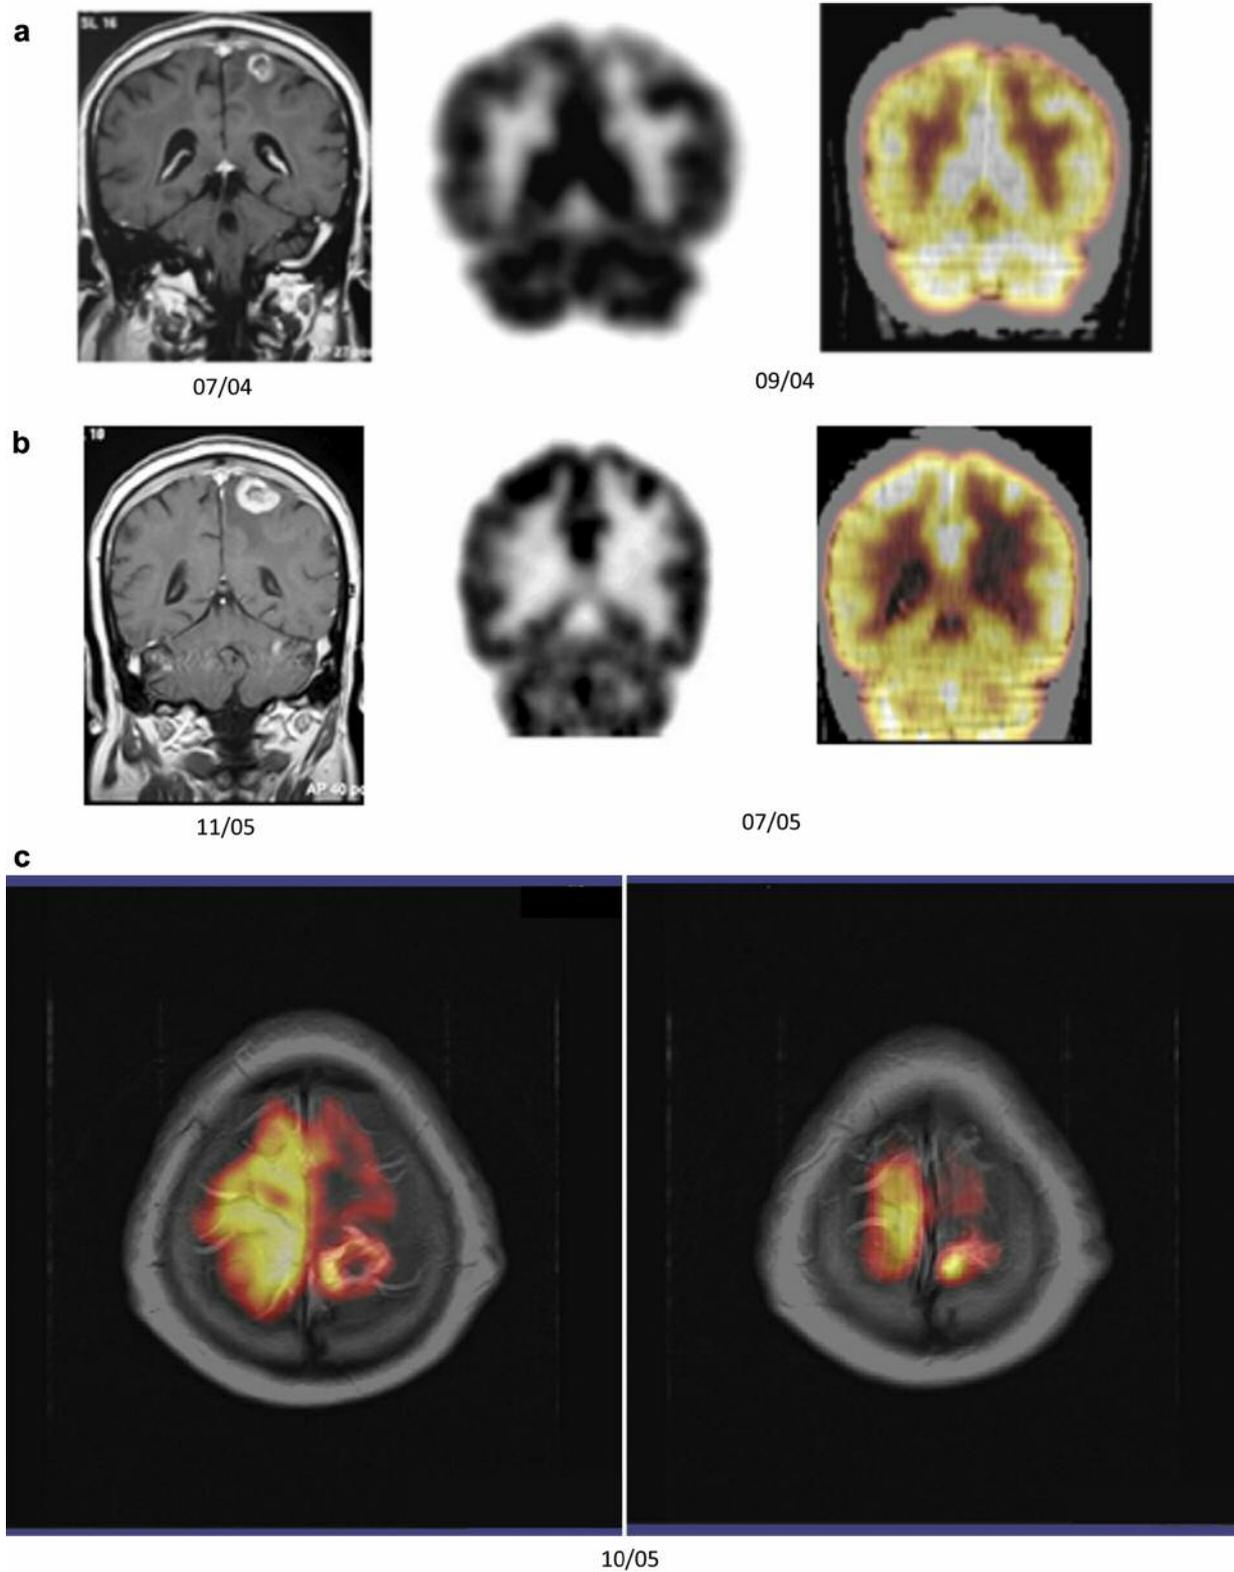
Patient MN 1a initial magnetic resonance imaging (MRI) scans (07/04), positron emission tomography scan (PET) and PET fused with computerized tomography scan (PET/CT) (09/04) showing adverse radiation effect (ARE) in the left parietal region of the cortex. 1b, PET/CT (07/05) shows slightly higher uptake in the same area than the previous studies, however the lesion was still considered ARE. 1c, Positron emission tomography fused with MRI scan (PET/MRI) (10/05) with definitely increased fluoro-deoxy-D-glucose FDG uptake in the treated area is suggestive of recurrence.
